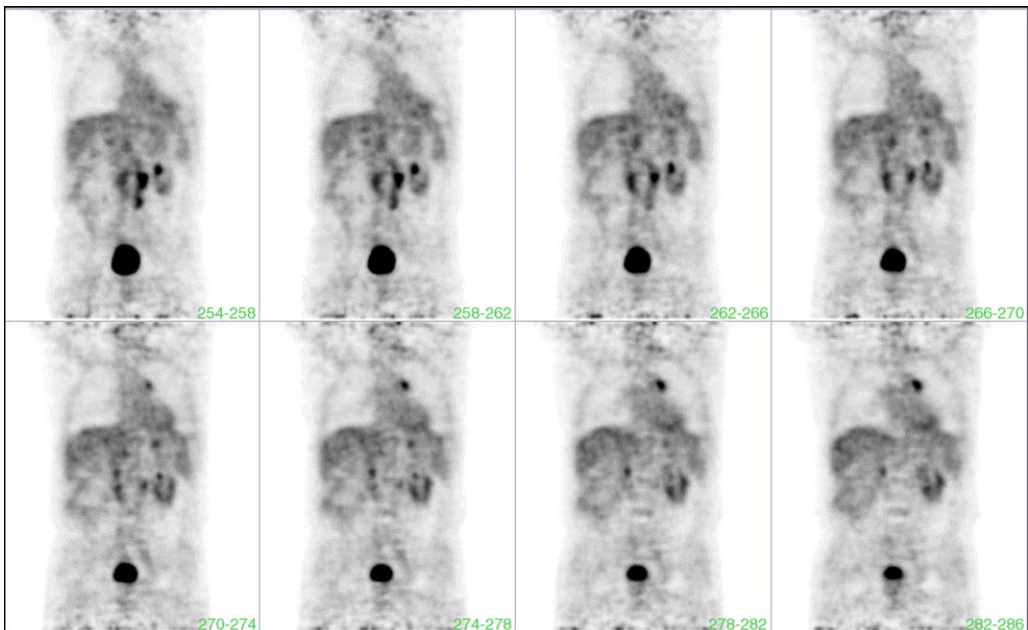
Coronal views of FDG-PET study show intense FDG uptake in the abdomen suggestive of metastatic lymphadenopathy from prostate cancer.
